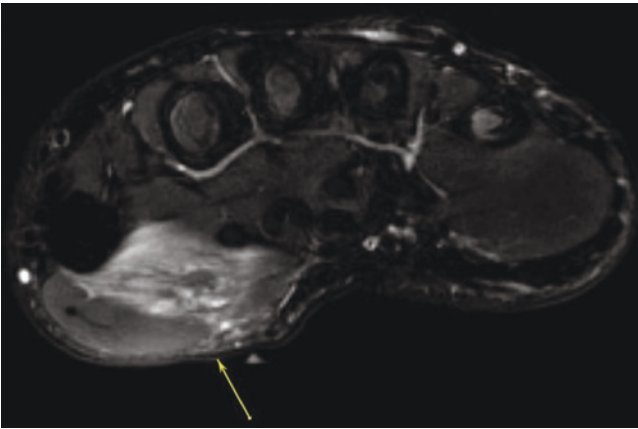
MRI from the right hand: expansion and diffuse signal abnormality of the flexor pollicis brevis muscle
